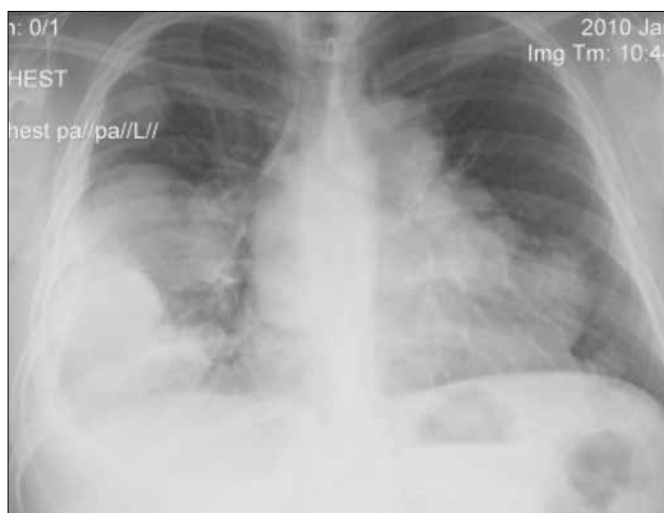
Control chest X-ray. Increase in size and number of metastases in both lungs. Disease progression.
